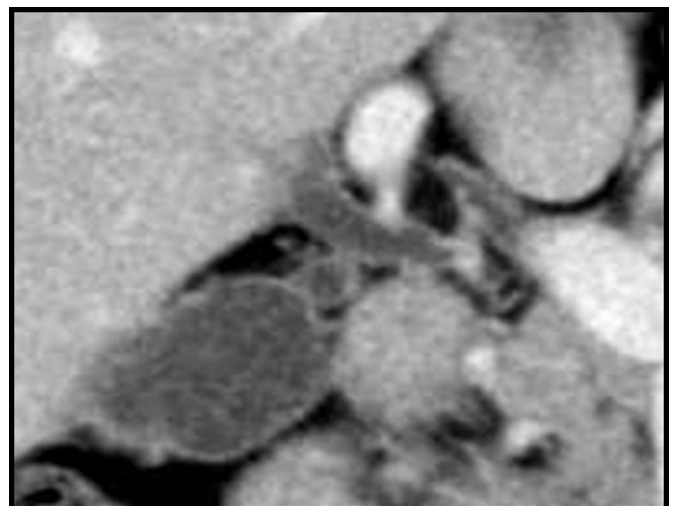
Contrast-enhanced computed tomography of the abdomen after 2 months of increasing the prednisolone dose showing common bile duct and gallbladder thickening.
